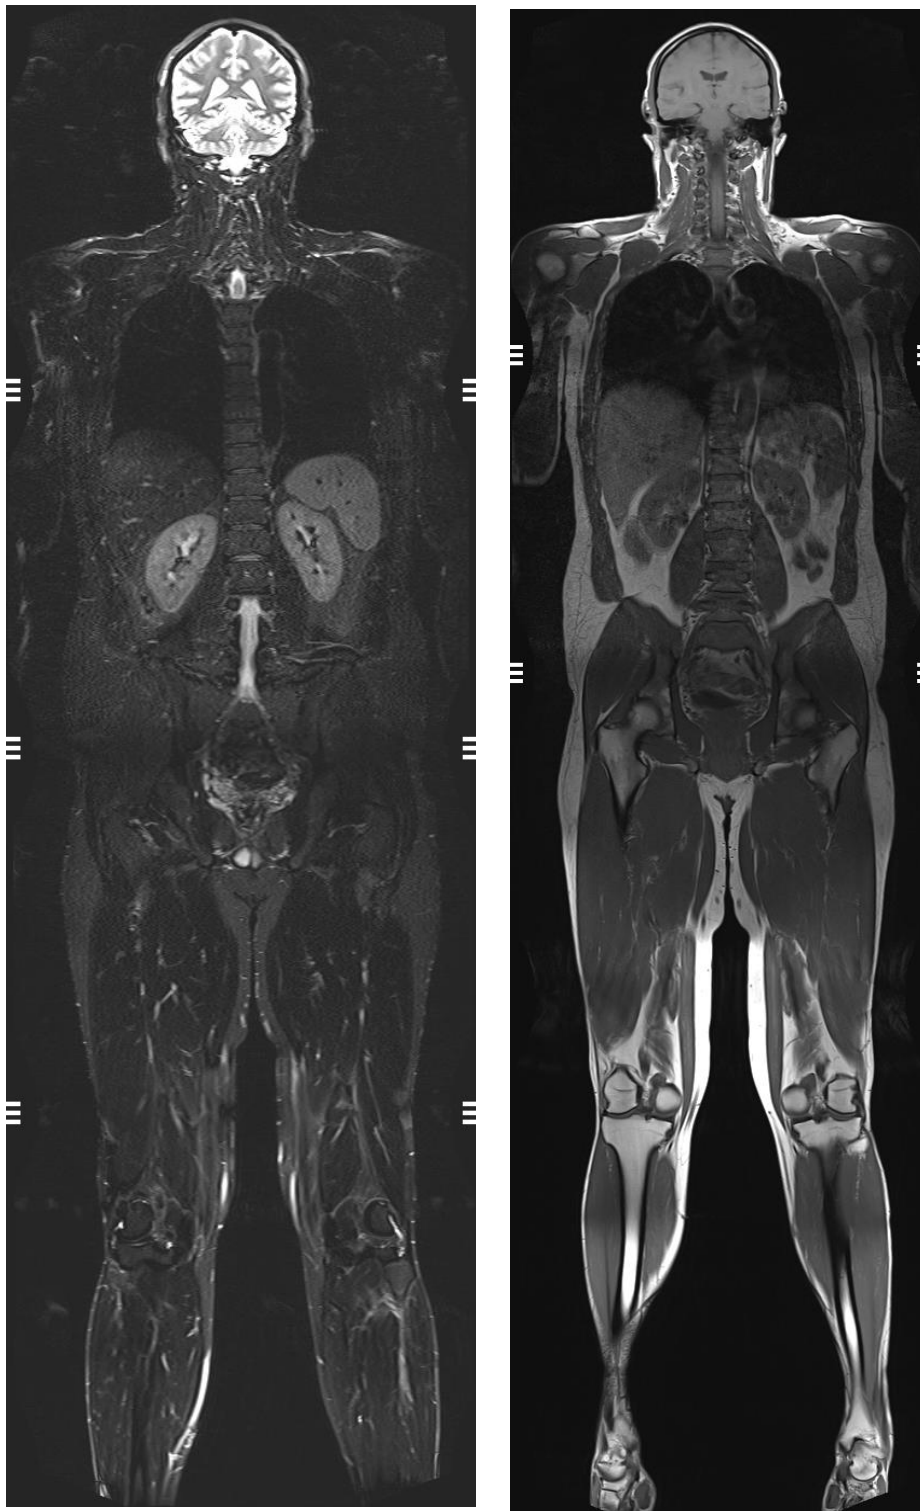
wb MRI. T2 STIR (left), T1w tse (right).
